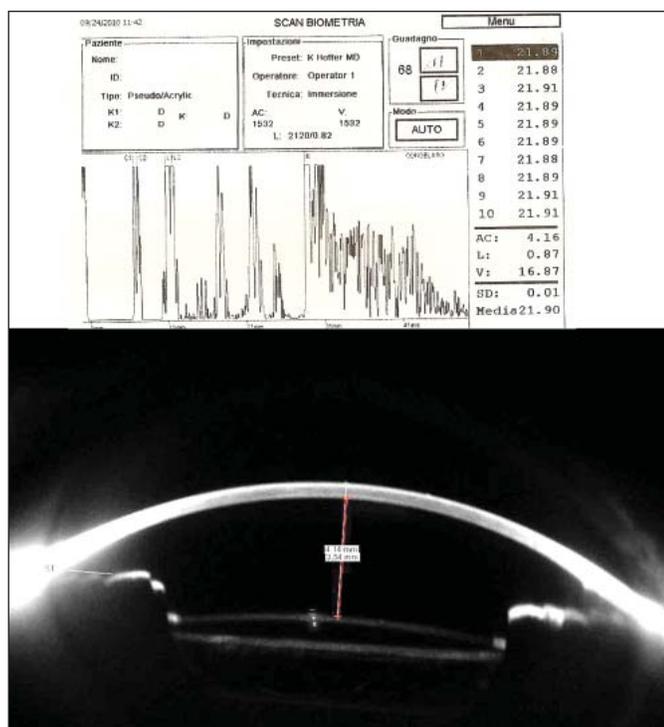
(Top) immersion ultrasound biometry shows a distance of 4.16 mm between the corneal epithelium (C1) and the anterior intraocular lens surface (L1). (Bottom) In the same eye, the caliper between the corneal epithelium and the anterior intraocular lens surface (white line) shows a distance of 4.14 mm, whereas the distance between the corneal endothelium and the lens is 3.54 mm (red line).
